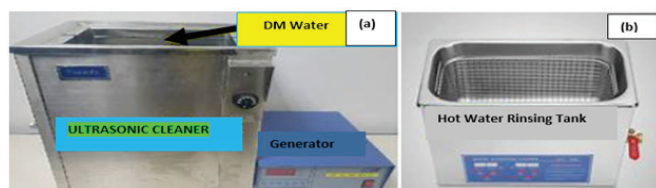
Ultrasonic cleaning machine (a) Ultrasonic chemical reagent tank (b) Hot water rinsing tank
